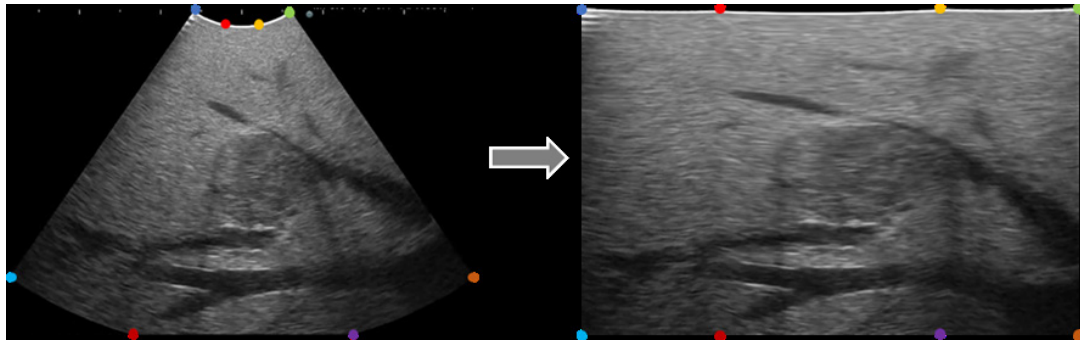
Ultrasound image of the liver transformed by piecewise affine transformation. The direction of signal propagation is unified vertically so that PLSN can be applied to the entire image.
